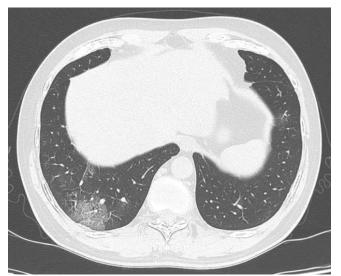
In a completely vaccinated, 56yr old COVID positive pt, axial sections of CT thorax at the level of lower lobes, shows a patch of ground glass opacities with inter and intralobular interstitial thickening involving subpleural location of posterobasal segment of right lower lobe. CTSS was 2 (mild).
